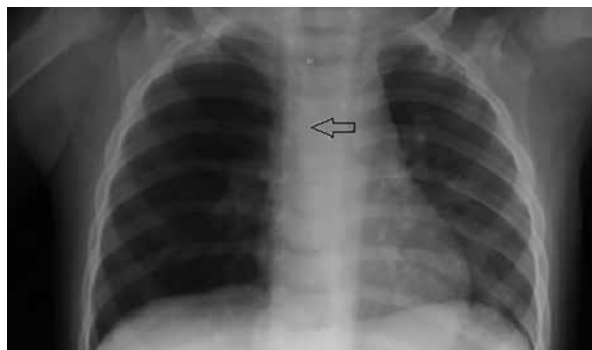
Initial chest radiograph showed tubular linear opacity in the right main bronchus
